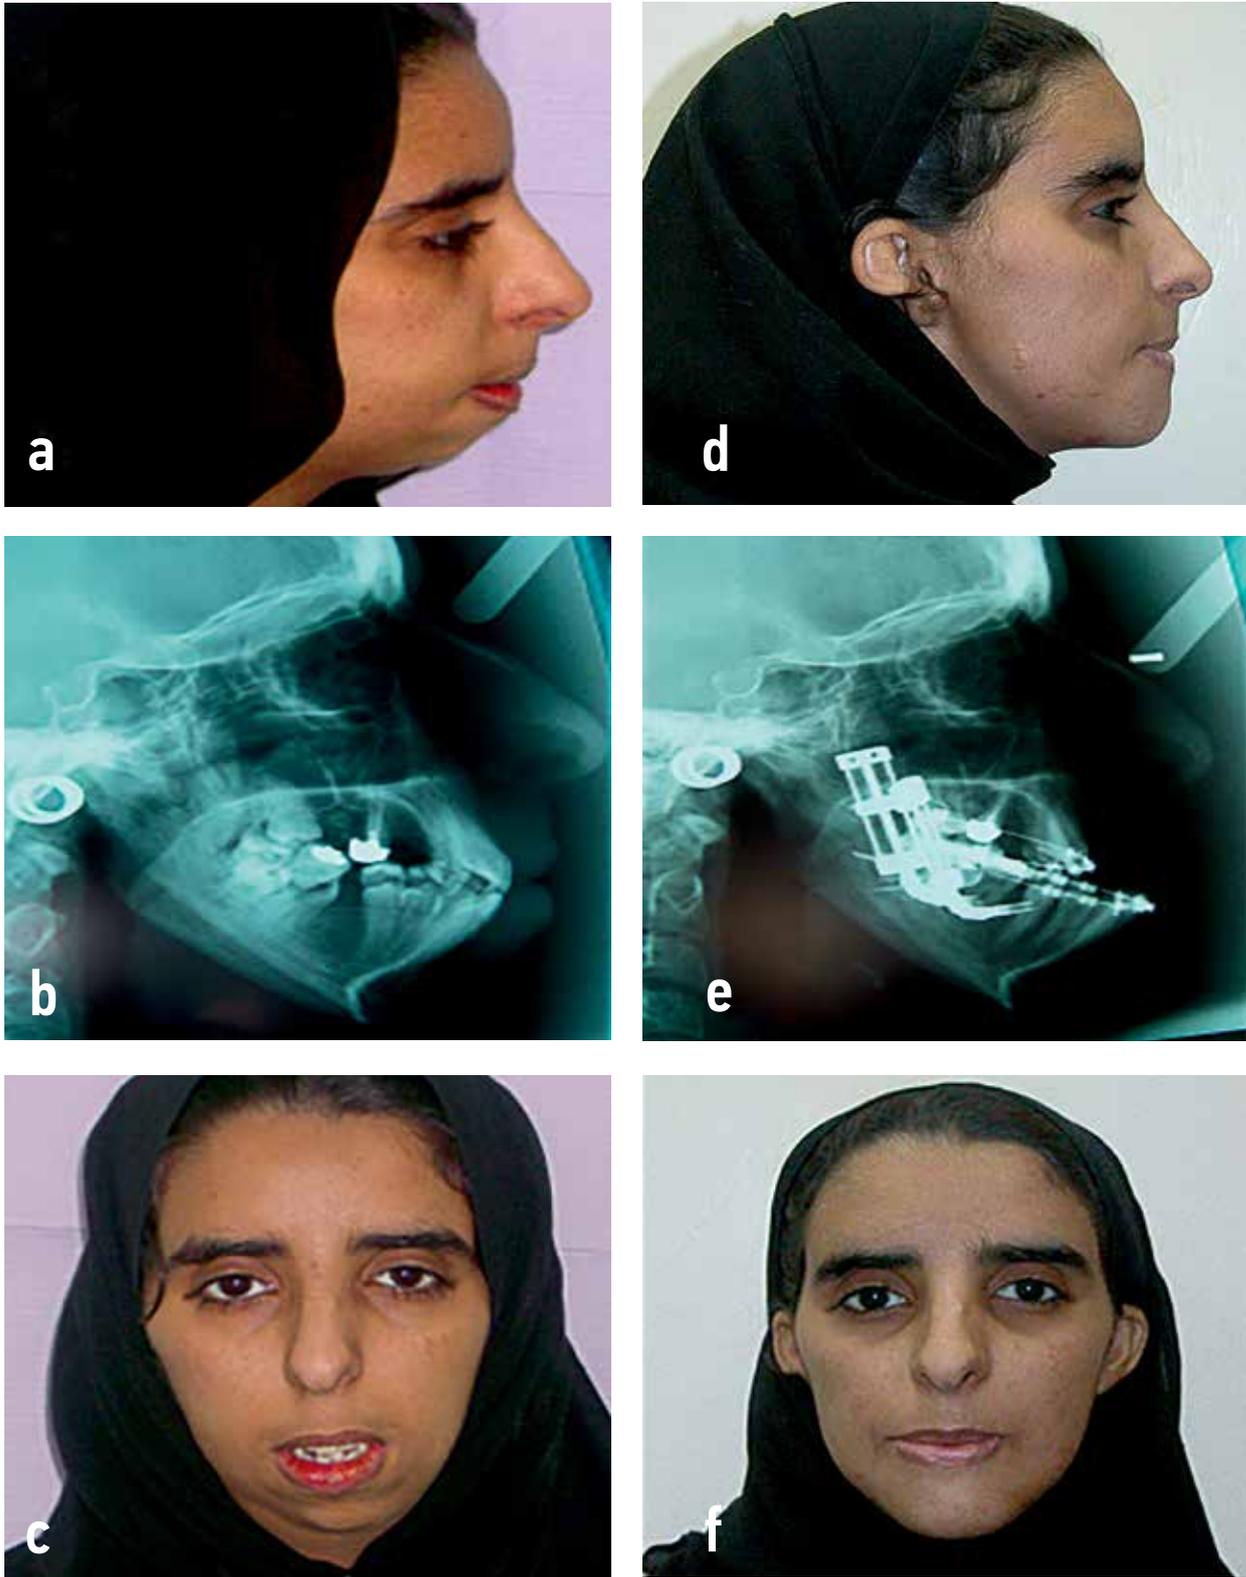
(A,B,C) pre-operative and cephalometric radiographs showing, facial harmony loss and airway collapse due to severe mandibular retrognathic problem caused by condyle resorption. Fig. 1 (D,E,F) post-operative regaining of facial harmony by mandibular distraction osteogenesis followed by double jaw orthognathic surgery.
